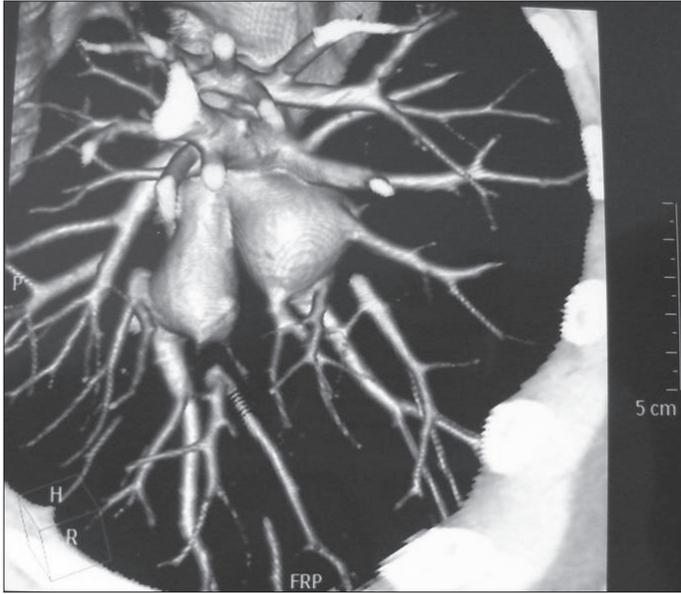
Multislice computed tomography angiography view of 2 separate pulmonary artery aneurysms
